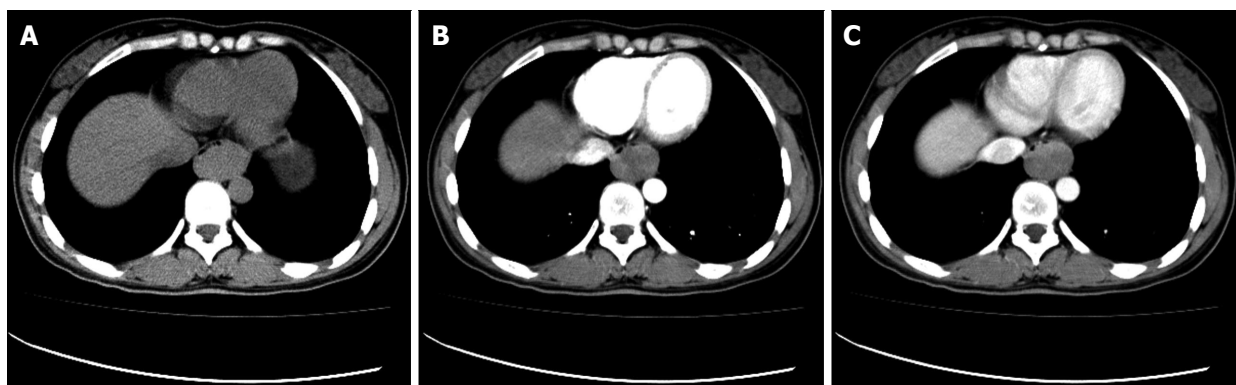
A 29-year-old female with leiomyoma. Esophageal leiomyoma shows sharply margined homogeneous mass in the lower third esophagus. These tumors show isoattenuating or slight hypoattenuating to muscle at non-enhanced computed tomography (A), moderate arterial (B) and venous (C) phase enhancement.
